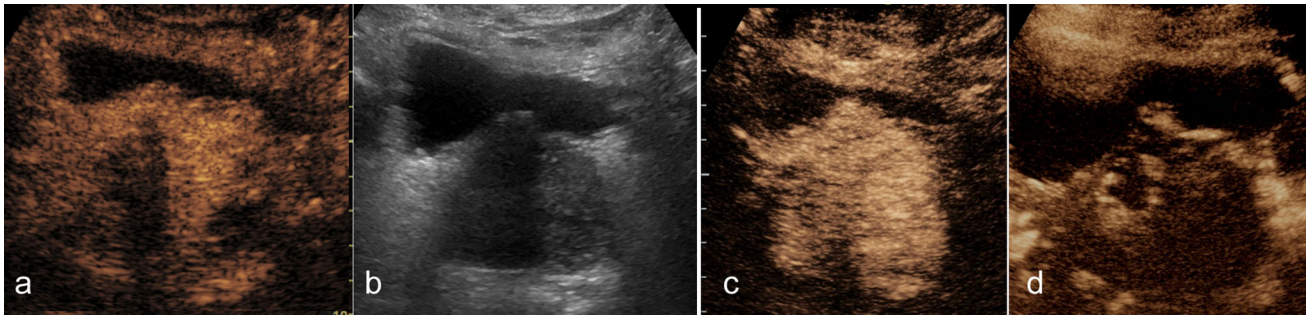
Representative sonographic images after initial PAE and rePAE. a On CEUS one day post-initial PAE, prostatic infarcts (non-enhancing areas) are demonstrated bilaterally, more prominent in the right hemiprostate. b On US 3 months post-initial PAE, prostate shrinkage can be appreciated. c On CEUS 4 years post-initial PAE, there is almost complete prostatic reperfusion and recurrence of prostate enlargement. Patient also reported severe symptomatic
